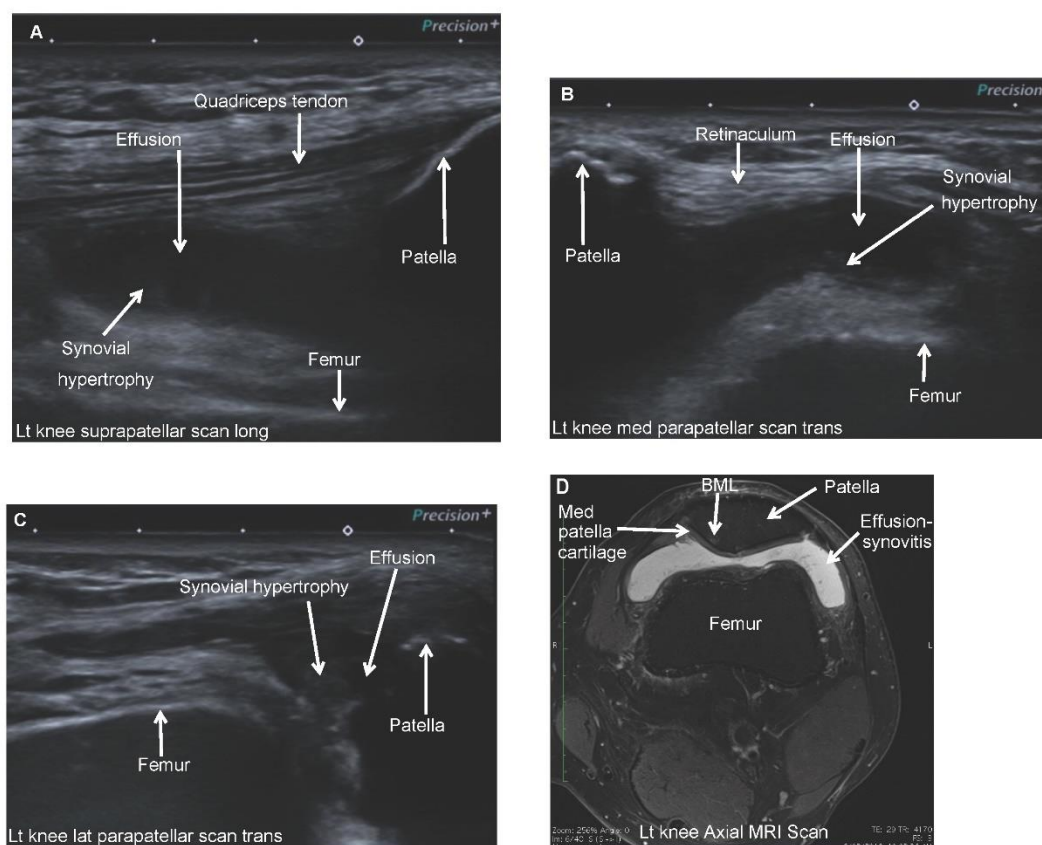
The demonstration of ultrasound and MRI synovitis from three synovial recesses of the knee in the same patient. A. OMERACT Grade 3 synovitis at the suprapatellar recess on a longitudinal scan. B. OMERACT Grade 3 synovitis at the medial parapatellar recess on a transverse scan C. OMERACT Grade 3 synovitis at the lateral parapatellar recess on a transverse scan D. MOAKS grade 3 effusion-synovitis on the axial non-contrast-enhanced MRI scan
